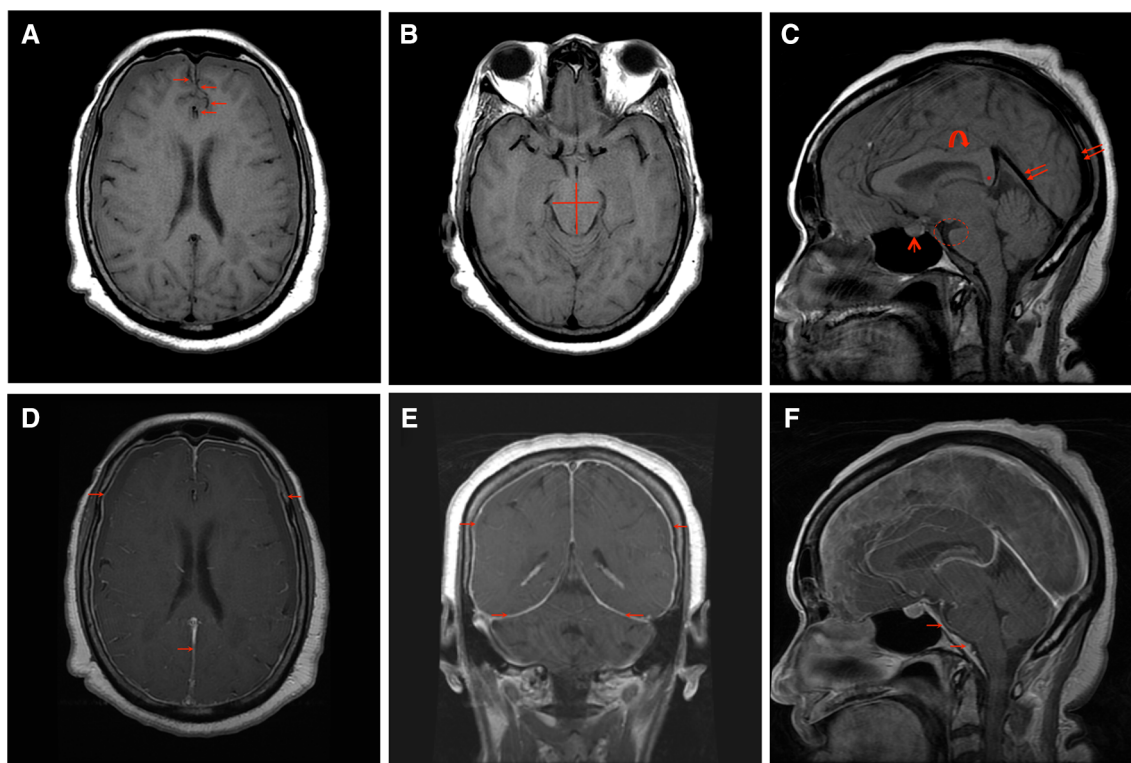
MRI brain with and without contrast. a T1 axial view shows subdural collections and engorged cortical veins (arrows). b T1 axial view shows increased anterior–posterior and decreased bipeduncular diameter of the mesencephalon (cross). c T1 sagittal view shows engorged venous sinuses (double arrows), effaced interpeduncular
